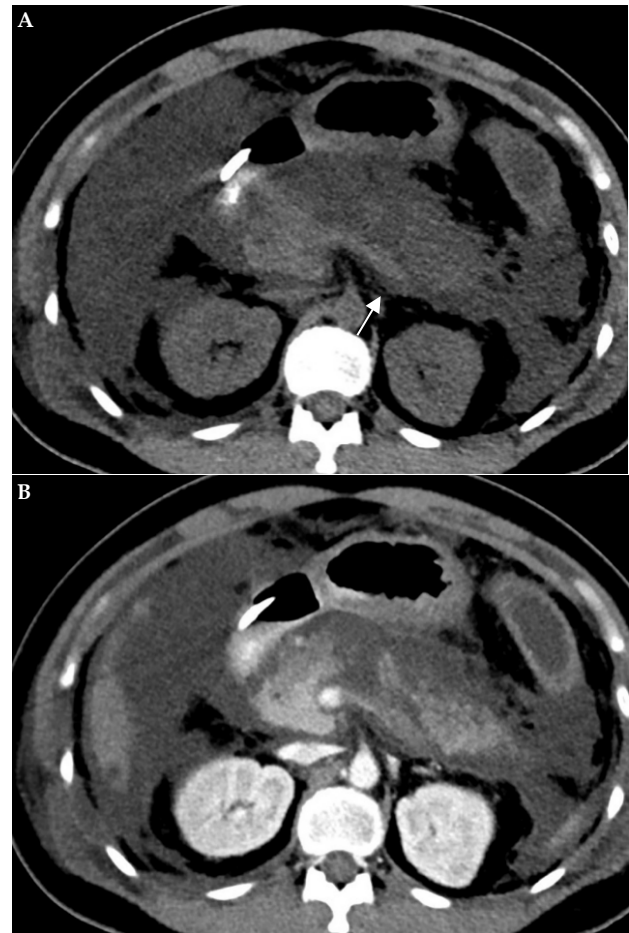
Abdominal CT imaging at presentation on precontrast (A) and postcontrast (B) scans. The pancreas was diffusely edematous with patchy hypoenhancing areas in the pancreatic body suggestive of necrotizing pancreatitis. There was a highly dense area without contrast enhancement in the splenic vein due to thrombosis (arrow).
